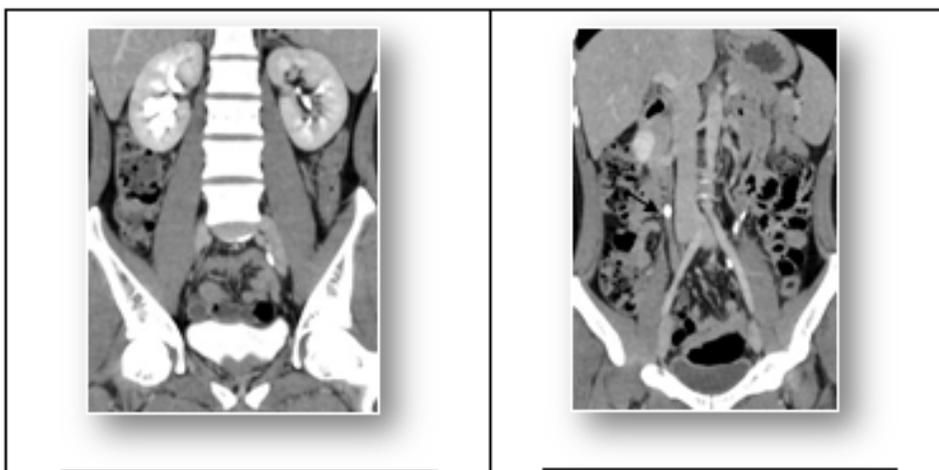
Coronal reformatted images of nephropelvic phase of CT Urographic study done using the 'Split-bolus technique', showing mild right hydronephrosis and a right ureteric calculus (black arrow).
